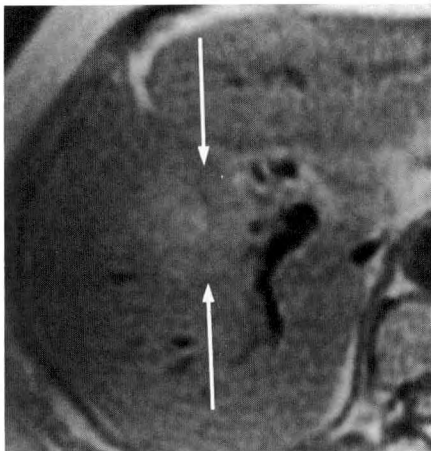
Axial MR images.
